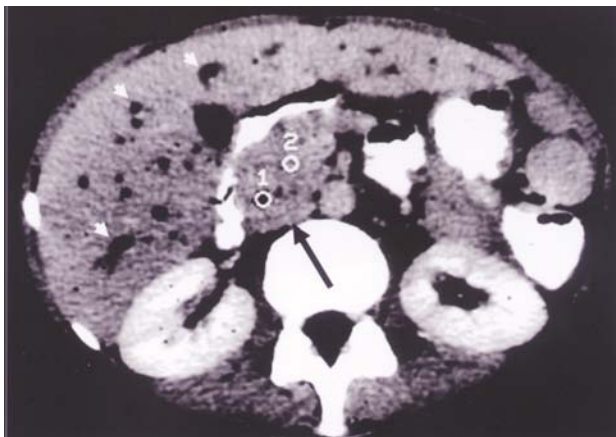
Axial contrast-enhanced CT demonstrates enlargement of the pancreas head (→) and intrahepatic biliary tract dilatation (↔).
